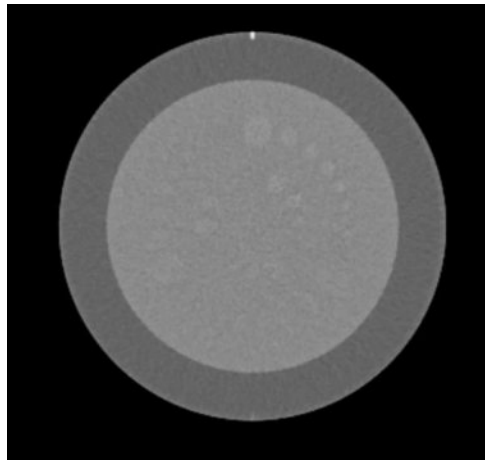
low contrast module in CT with a high $IQFinv$ value
